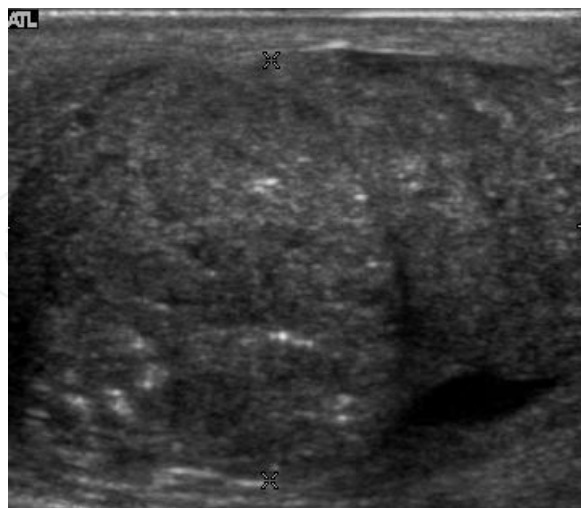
Embryonal cell carcinoma. Longitudinal ultrasound image of the testis shows an irregular heterogeneous mass that forms an irregular margin with the tunica albuginea
